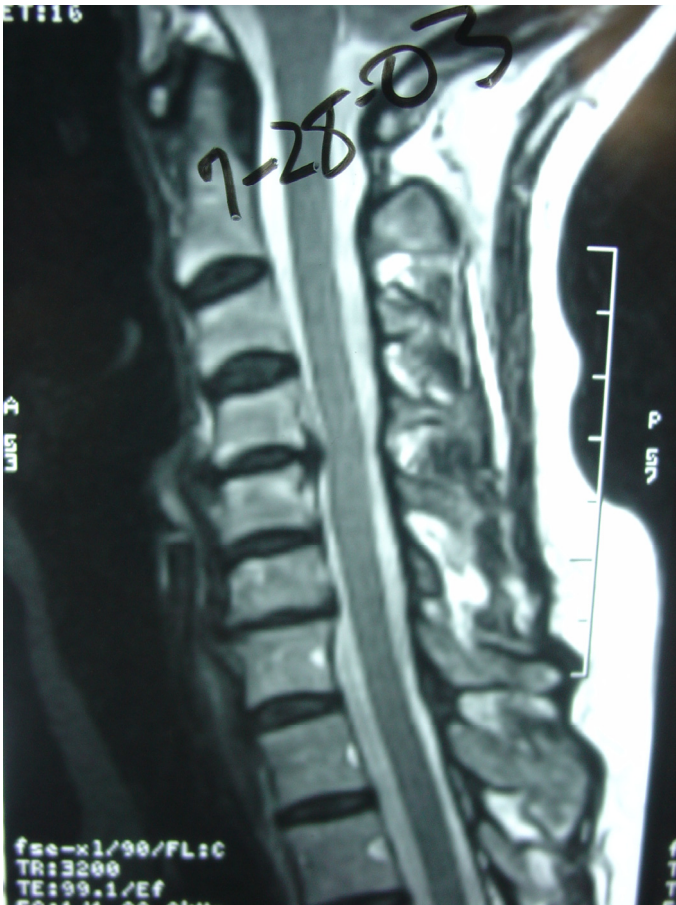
this MRI is ordered due to persistent right arm pain and now shows that the C4-5 disc is herniated to contact the anterior thecal sac.
